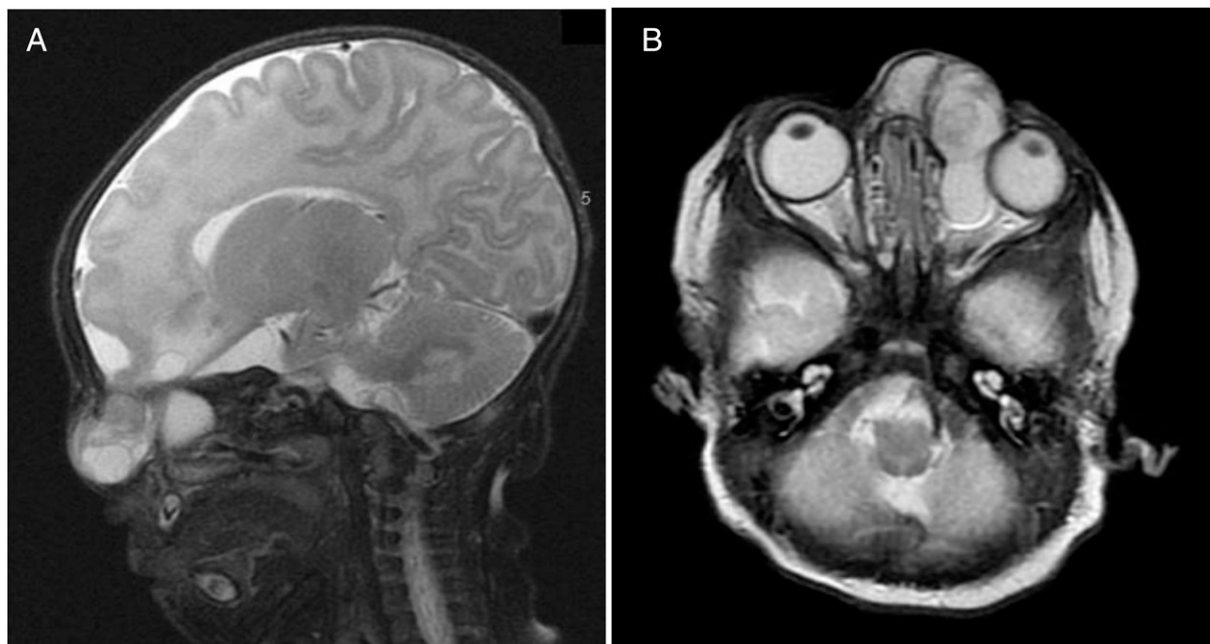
Magnetic resonance imaging scans. A. Sagittal view. B. Axial view.
